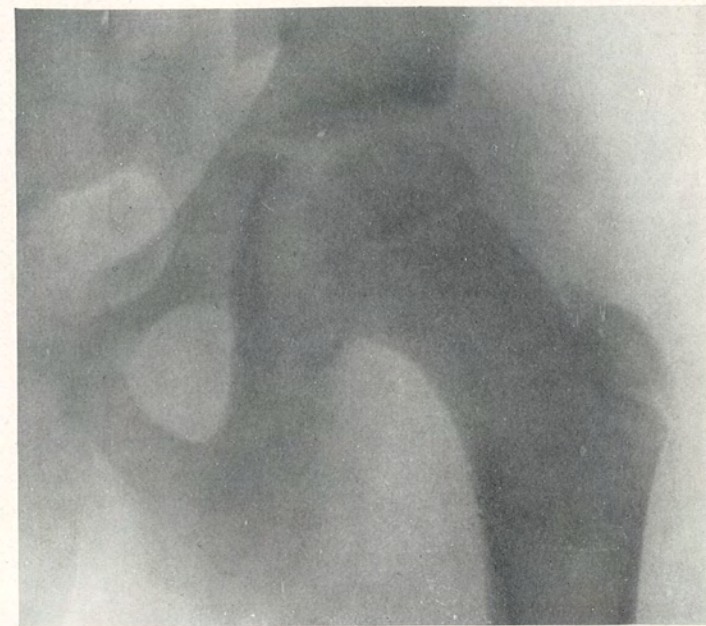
Case X. X-ray No. 9437. Showing femoral head in normal position after reduction.
